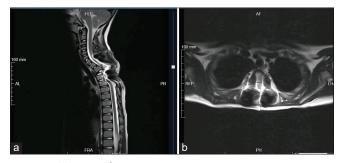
Two-month post-operative magnetic resonance imaging: (a) T2 sagittal and (b) T2 axial views showing sagittal alignment maintained without aneurysmal bone cyst mass recurrence.
